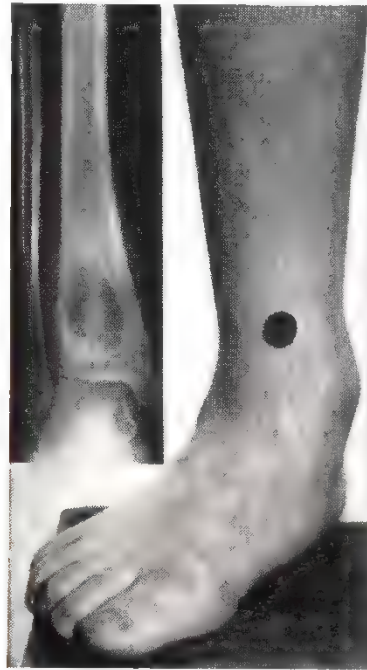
Site of maximum tenderness over a Brodie's abscess of lower end of tibia. Inset, radiograph displaying intra-osseous abscess.
